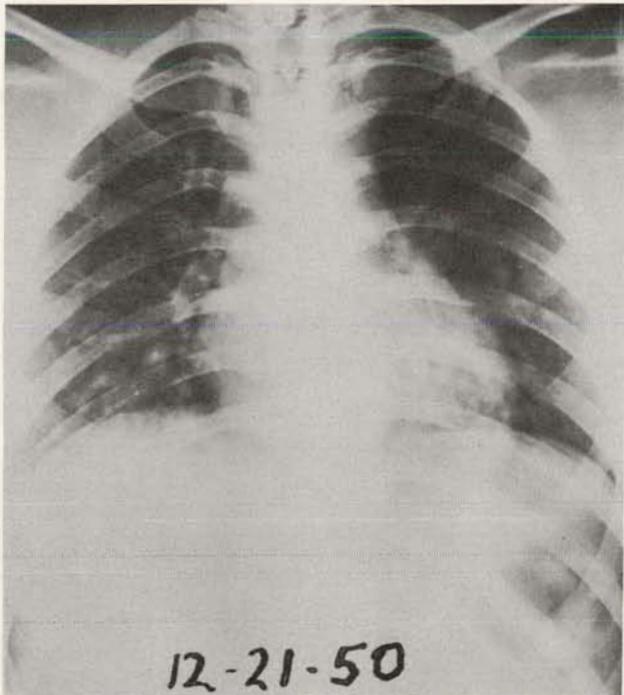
Roentgenograph of chest, December 21, 1950. Patient, 17-year-old girl, had papillary carcinoma diagnosed by biopsy of nodule in right lobe of thyroid and right cervical lymph node. Nodule in thyroid first noted in 1946. I^{131} uptake in December, 1950, was 60% in 24 hrs.
